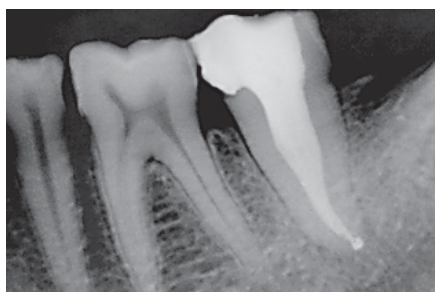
Radiograph of Post-Obturation Restoration
